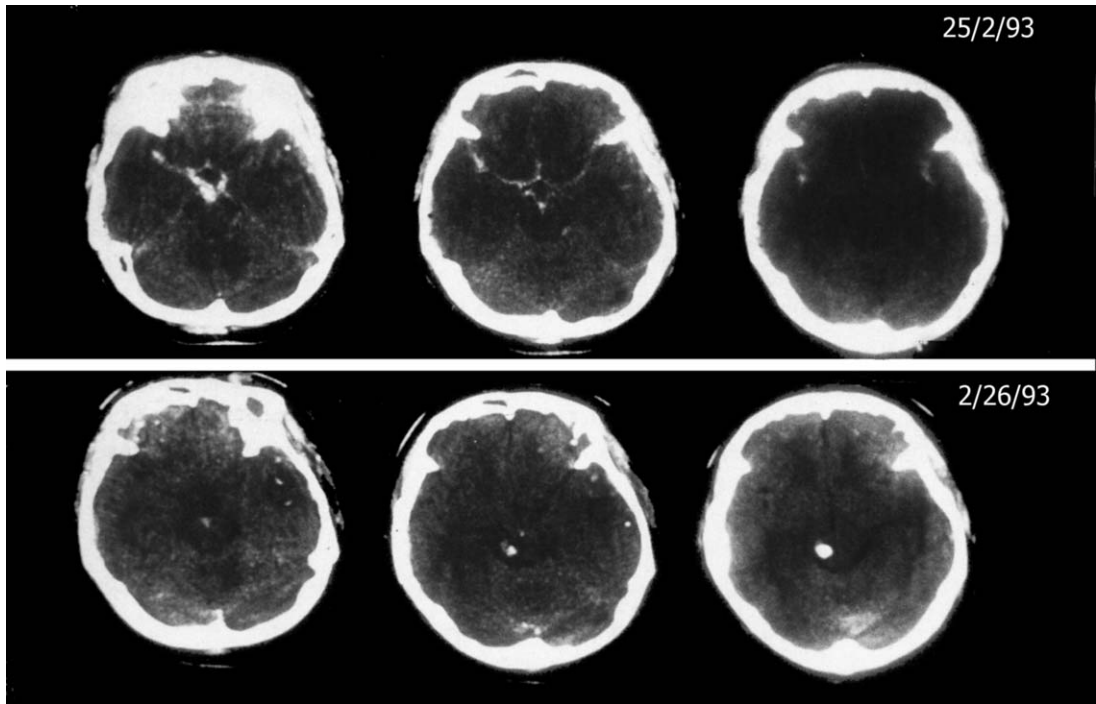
A computed tomographic scan of case 2.
